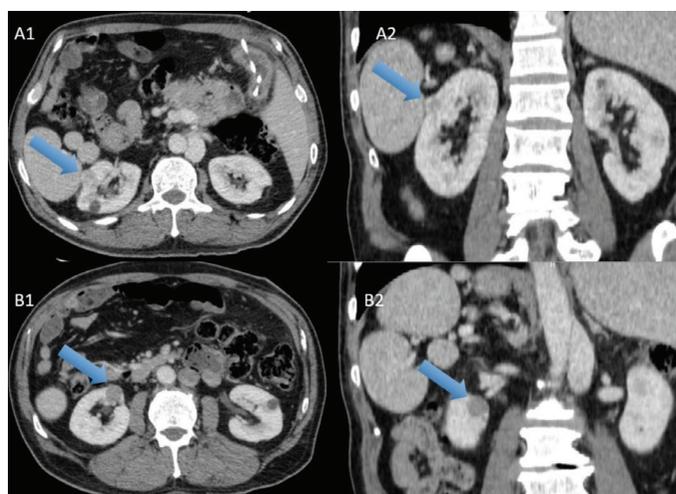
Patients computed tomography images. The masses are indicated by arrows
